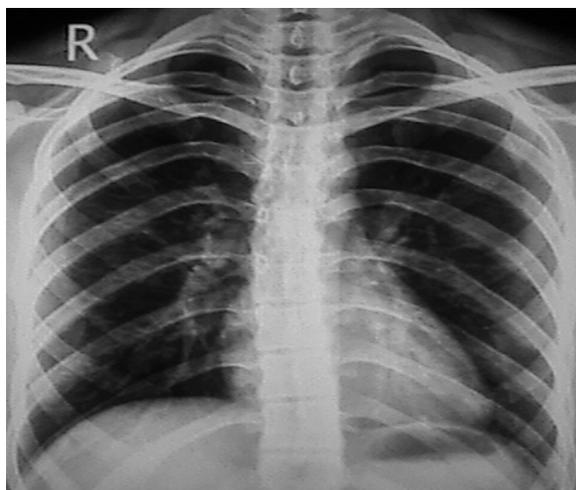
Follow-up radiograph showing clearing of left basilar shadowing
